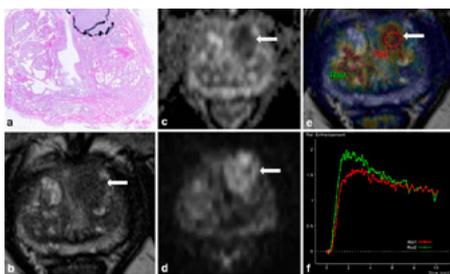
A 67-year old patient with an anterior located Gleason score 7b prostate cancer in the transitional zone (PSA 5.69 ng/ml), encircled on the whole-mount step-section slide (a): The carcinoma (arrows) shows low signal on T2-weighted images with ill-defined margins (b), diffusion restriction on diffusion-weighted imaging (c, d), and hyperperfusion on dynamic contrast-enhanced MRI (e: red circle on perfusion map) with a focal plateau curve (f: red curve). An area with hyperplastic nodules appears unsuspecting in T2-weighted images (b), diffusion-weighted imaging (c, d), but shows hyperperfusion on dynamic contrast-enhanced MRI (e: green circle on perfusion map) with a focal wash-out curve (f: green curve), which is even more pathological (PI-RADS 5) than the perfusion of the carcinoma.
